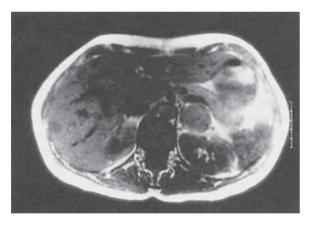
MRI scan of left adrenal phaeochromocytoma.
